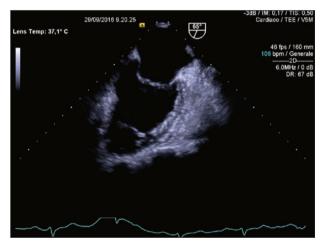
Transesophageal echocardiography evaluation eight weeks after treatment with dabigatran etexilate.
